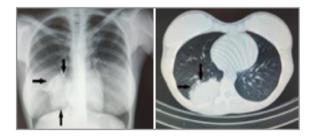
Pulmonary lesions in the patient's chest X-ray and Thorax CT imaging
